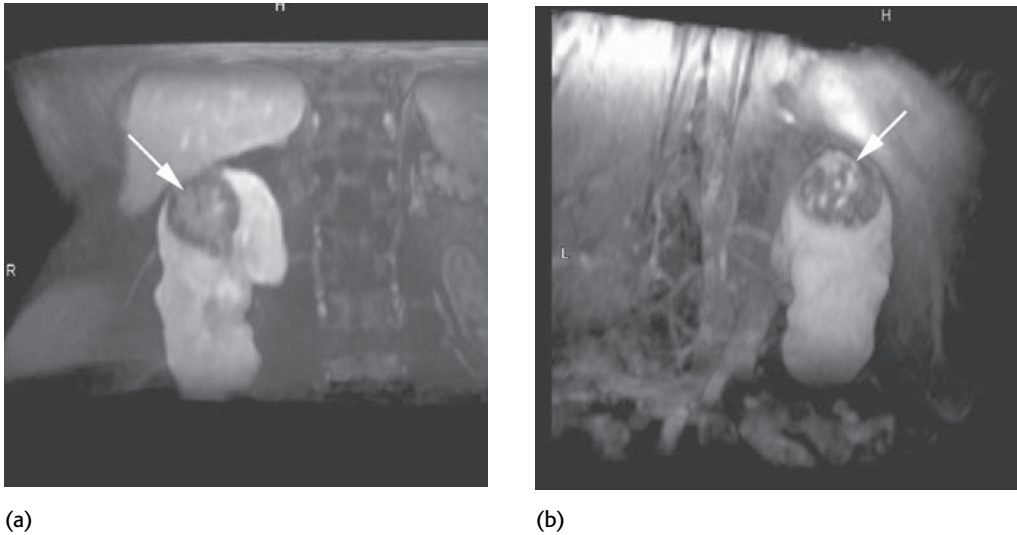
3D volume-rendered MR images. Anterior (a) and posterior (b) views show the right upper pole mass (arrow); these images are reconstructed from thin-section T1-weighted fat-saturated MR images.
